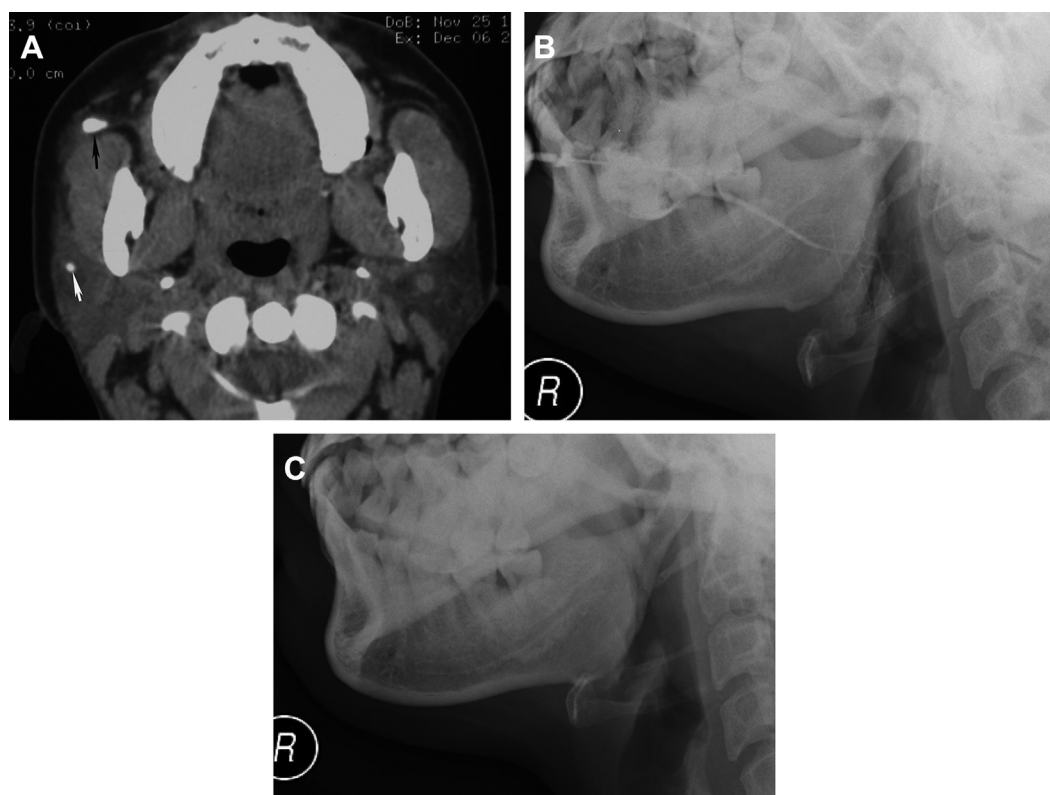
A 48-year-old woman with a 7-year history of sialoliths in the right parotid gland. The stones were removed using method 3. A, Axial computed tomography (CT) showed a small stone in the parenchyma of the gland (*white arrow*) and a large stone in the distal segment of the Stensen duct (*black arrow*). B, This patient remained asymptomatic 9 months after the surgery. Follow-up sialography showed approximately normal shape of the main duct. C, Persistent contrast was not detected on the functional radiograph.
